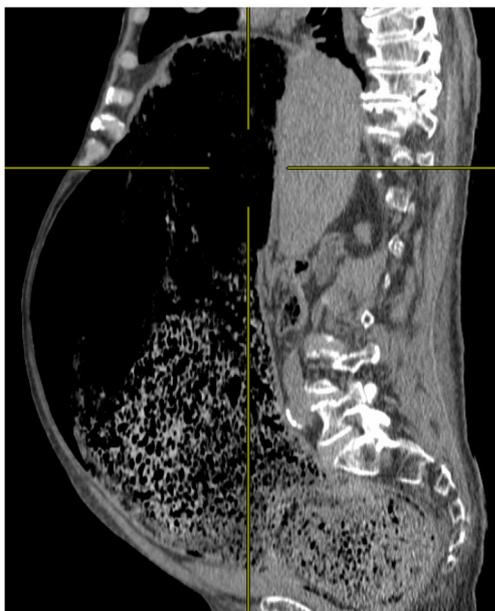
Abdominopelvic CT scan, sagittal view, without injection of product contrast: giant fecaloma extending from the lower rectum to the right diaphragmatic region. The liver is repressed posteriorly; the left colon is flat and compressed
